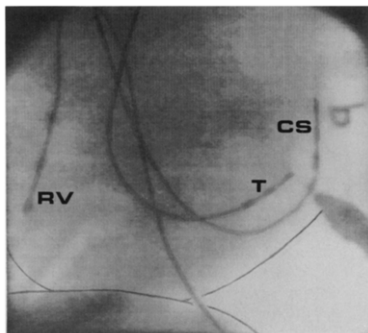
Left anterior oblique fluoroscopic image of the transponder (T) catheter in the left ventricle in the same position as in Figure 4. Although the posterolateral orientation of the catheter is evident, the proximity of the mitral apparatus is not as apparent as it is on the corresponding echocardiographic view. The cardiac silhouette and diaphragm have been outlined for clarity. CS = coronary sinus catheter; RV = catheter in the right ventricular apex.
